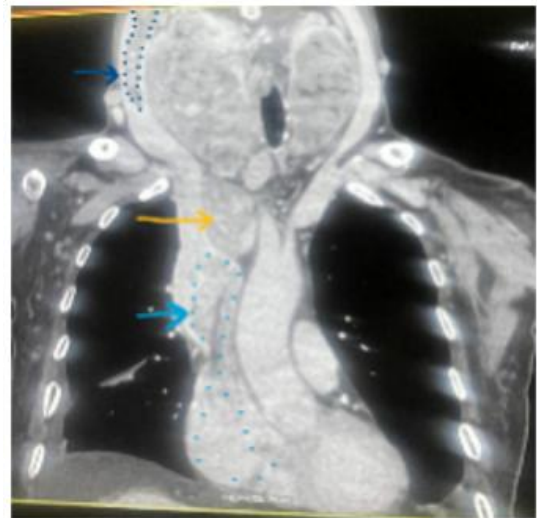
CT scan demonstrating a large heterogeneously enhancing thyroid gland $12 \times 6.5 \times 11.4$ cm with retrosternal extension 4.2×2.4 cm (yellow arrow), thrombus extending from right superior thyroid vein into the right IJV of approx. 6.2cm (upper blue arrow), inferiorly thrombus extending from bilateral ITV into left innominate, SVC & Right atrium (lower blue arrow).
